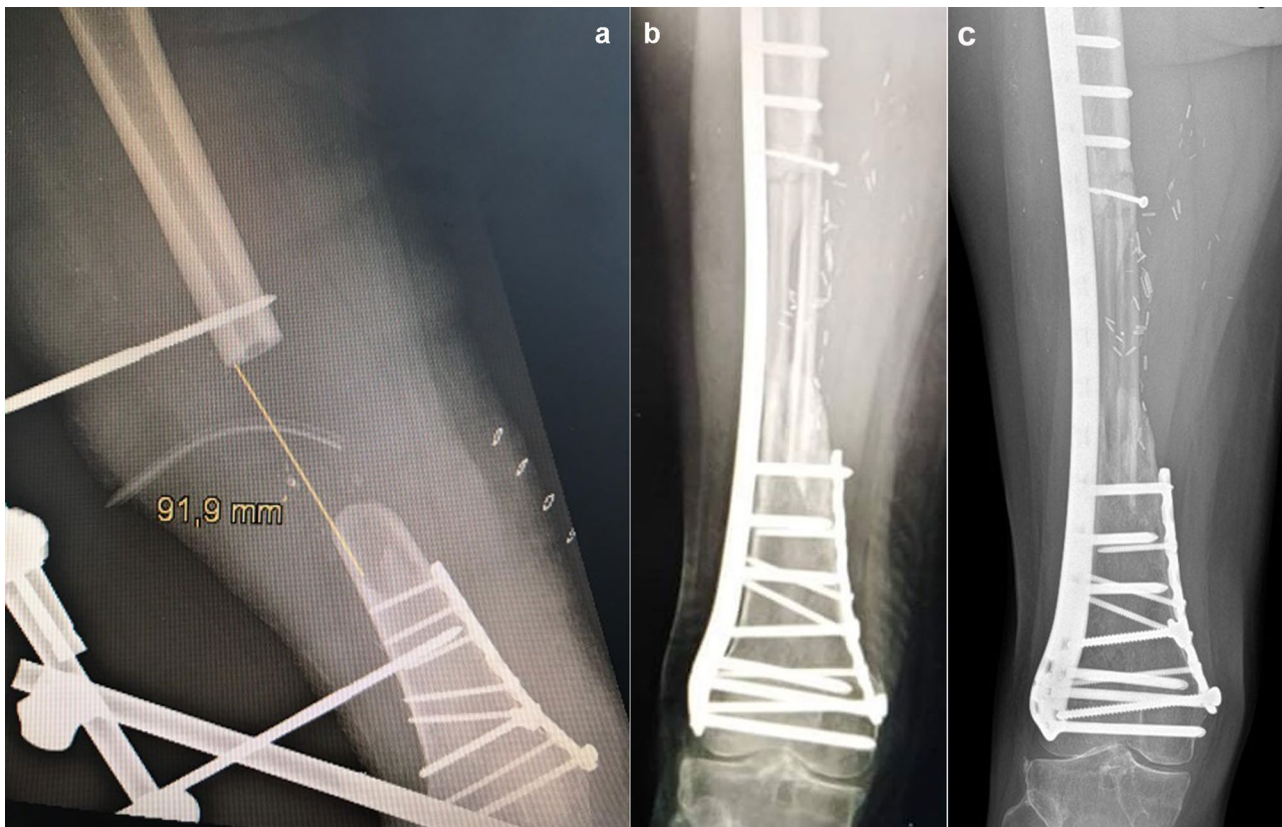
A 33-years-old female polytraumatic patient with a medial diaphyseal femoral fracture – result after 12 months. X-ray before (a) and after (b) and result after 3 years (c)
